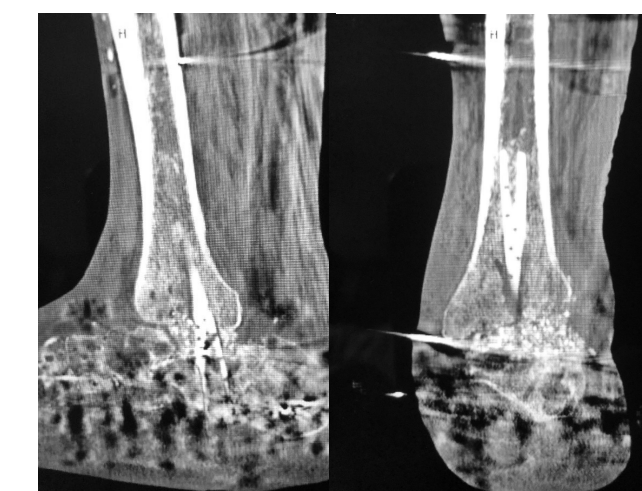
CT scan obtained 5 months post-operatively demonstrating tibio-talo-calcaneal fusion with incorporation of fibular autograft.
